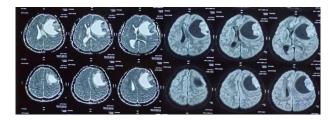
Magnetic resonance imaging of the brain revealing a large lobulated solid cystic mass lesion in the right frontal lobe with a mass effect and a midline shift.
